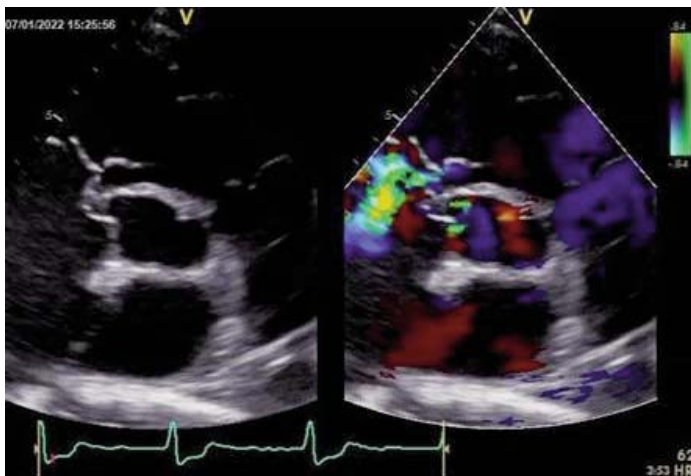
Parasternal short axis view of transthoracic echocardiogram showing ruptured sinus of Valsalva aneurysm.
